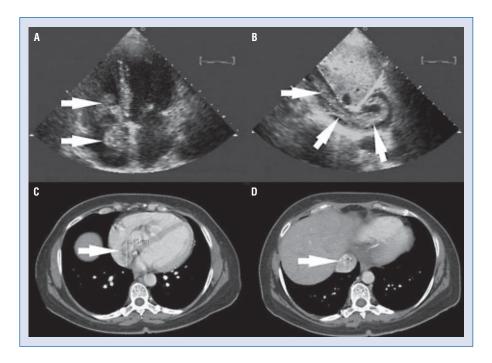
On echocardiography, (A) the right atrial thrombus of the renal cell carcinoma (arrow) was soft, friable and mobile, and obstructed the mitral orifice; and (B) the inferior vena cava thrombus (arrow) was serpentine-shaped with an uneven density. On computed tomography, (C) the right atrial thrombus (arrow) 8×4 cm in size was slightly hypoattenuated compared to its adjacent tissue; and (D) the inferior vena cava thrombus (arrow) was hyperattenuated.
